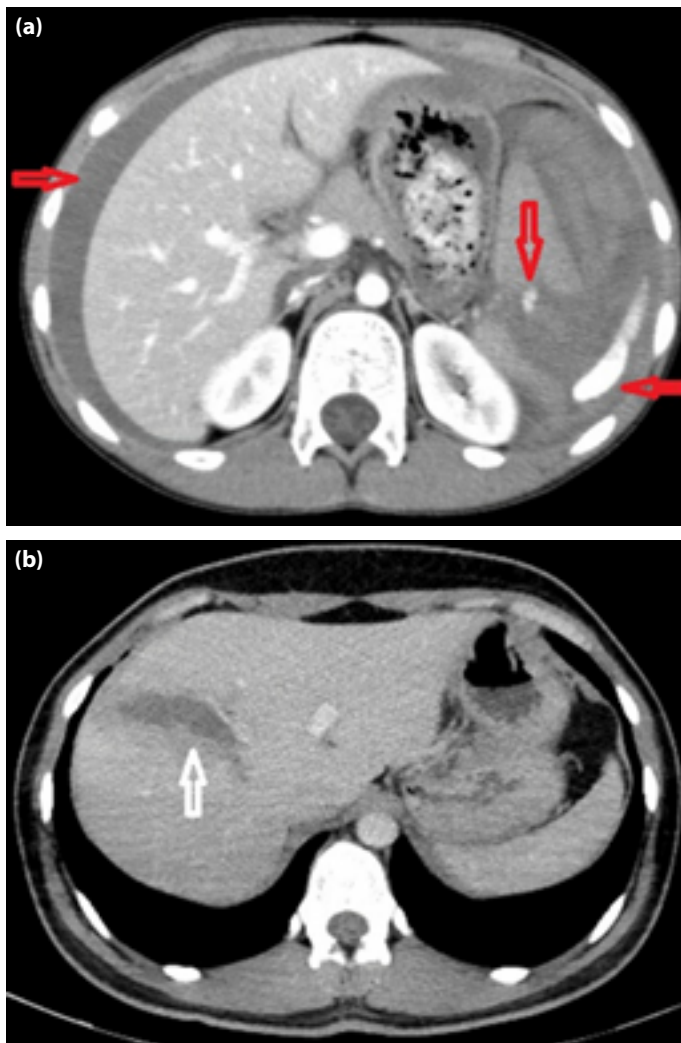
(a) A large splenic laceration with active intraparenchymal hemorrhage, contrast extravasation adjacent to the spleen, and hemorrhage extending toward the liver is observed (red arrows). The findings are consistent with an AAST grade 5 splenic injury. (b) Liver laceration in a 23-year-old woman with a handlebar injury to the right upper abdomen. Axial contrast-enhanced CT image shows an AAST grade 3 laceration (arrow) in the right hepatic lobe.
